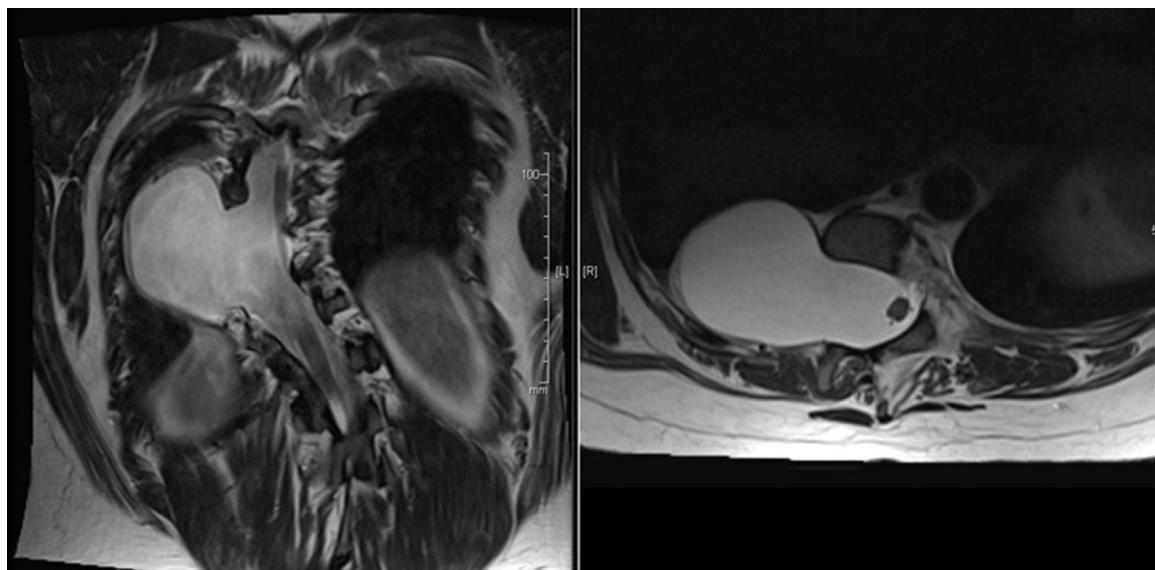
Coronal and axial views of MRI thoracic spine T2 sequence showing large meningocele-associated dural ectasia with cord displacement.
